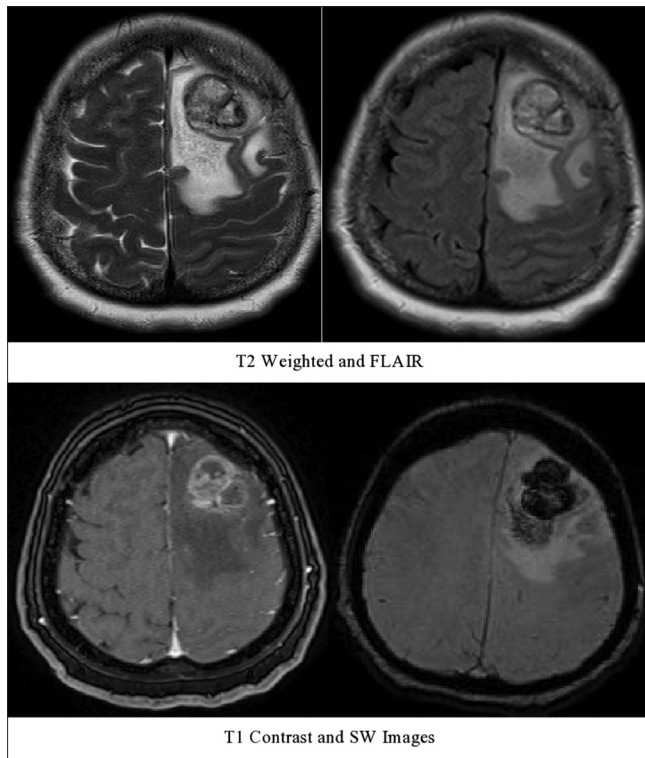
T1 Contrast, SWI, T2 Weighted, FLAIR, DWI and ADC mapping 49 Years female presented with headache since 7 days sudden in onset severe in intensity, more on the left frontal region which relieved on taking medication, history of weakness in right upper limb, difficulty in combing hair and mixing food. A fairly-defined intra axial enhancing lesion with multiple central hyperintensities on T2 weighted images and surrounding peritumoral edema in the left high frontal lobe showing diffusion restriction in the peripheral enhancing solid portion of the lesion on DW images (mean ADC: $0.81 \times 10^{-3} \text{ mm}^2/\text{s}$). HPE Report: Section studied showed features of metastatic papillary adeno carcinoma. Diagnosis: Left frontal metastatic papillary adeno carcinoma
